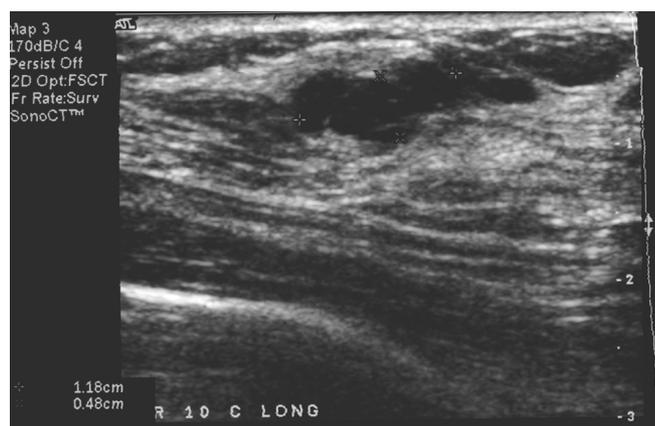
Appearance of suspicious mass in breast tissue on diagnostic ultrasound, which was designed to be part of the scanhead of the present system for image guidance and precise targeting.
